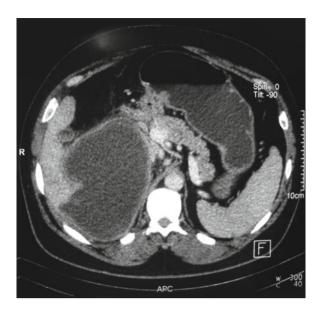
Axial view CT scan showing a large heterogeneous cyst adherent to the right hepatic lobe with retroperitoneal growth
